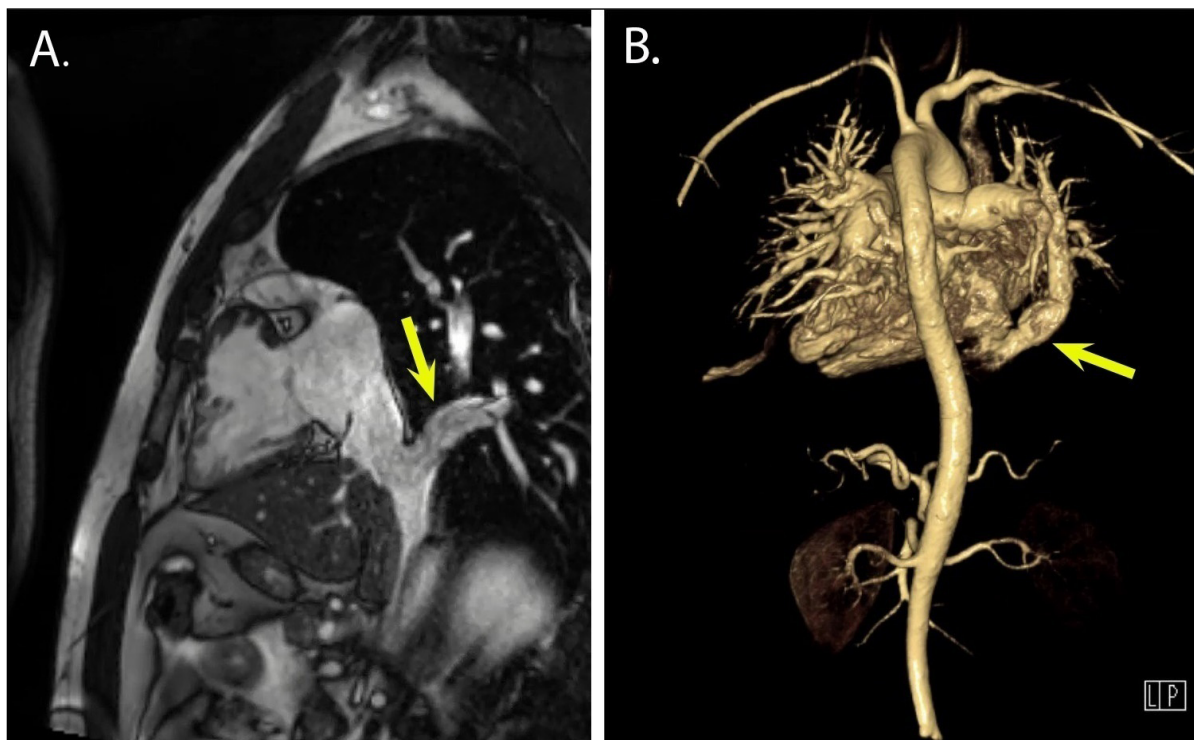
Magnetic resonance imaging of the scimitar vein from a (A) lateral and (B) posterior 3-dimensional-reconstruction view. The yellow arrows point at the scimitar vein.
